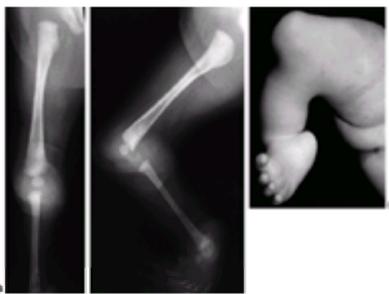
A, B: Radiographs of an infant with a type I tibial deficiency of Kalamchi and Dawe (Type 1a of Jones et al.), in which the entire tibia is absent. There was no extensor mechanism and no proximal tibia. If there were a proximal remnant of tibia that would later ossify, this would be a type 1b deficiency of Jones et al. C: The clinical appearance with the medial deviation and severe equinus of the foot, and the absence of any tibial structure below the distal femur.
